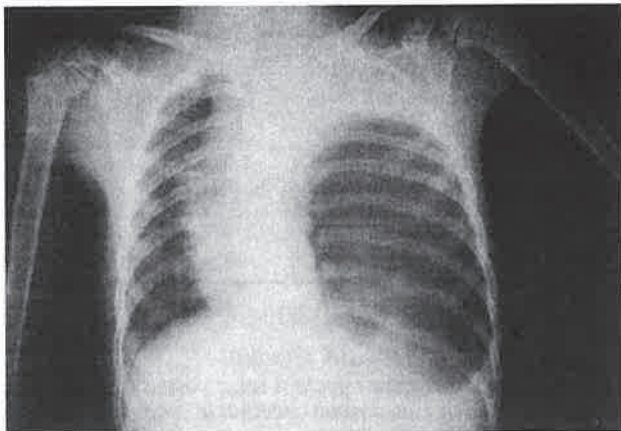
Plain x-ray of the chest with a big coil of air filled structure in the left hemithorax
